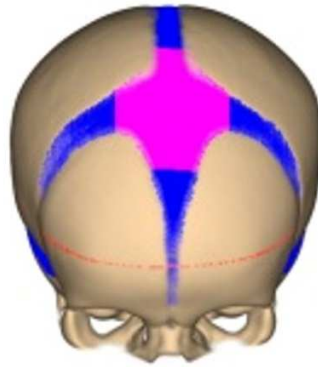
3D surface visualization of the cranial bone probability map, anterior fontanel area (colored in pink), reconstructed fontanels and sutures by proposed algorithm in [5] (colored in blue) and scalp eliminated head circumference of the CT template (red line).
